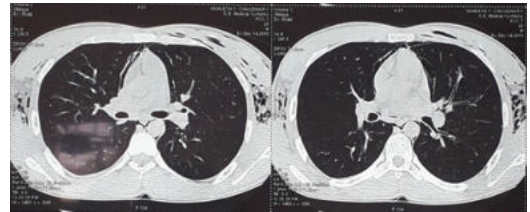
2- CT Thorax showing pneumomediastinum and subcutaneous emphysema bilaterally.
